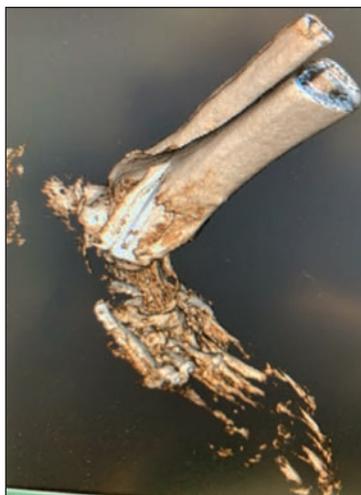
Remodeled 3D image of patient's foot based on obtained CT imaging. Bony degeneration of the midfoot (cuboid-calcaneal and metatarsal) region evident with soft tissue inflammatory changes present.
